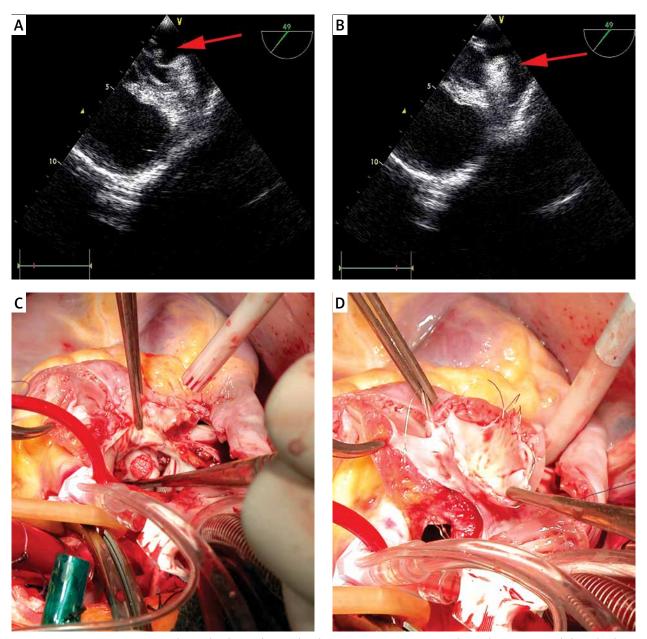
A, B – Trans-esophageal echocardiography demonstrating a mass in the right atrium and detached device, C, D – intraoperative finding
